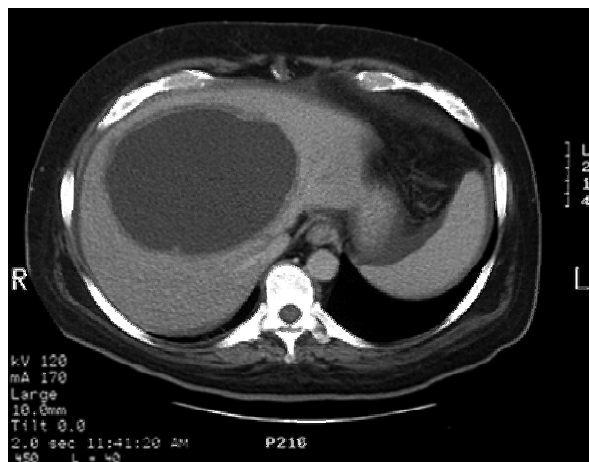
A Plain CT scan demonstrates an amoebic abscess in the right liver.
